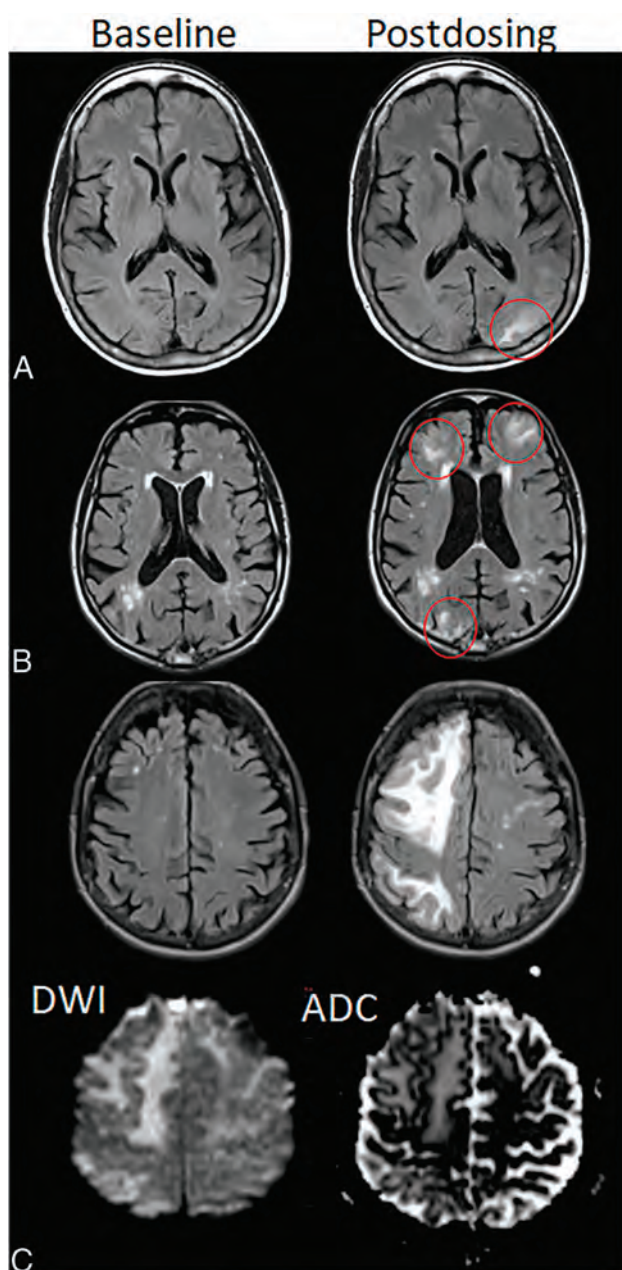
ARIA-E, parenchymal edema. Axial T2-FLAIR images from 3 separate patients at the time of the pretreatment baseline (*left*) and on a monitoring examination following initiation of anti-amyloid monoclonal antibody therapy (postdosing, *right*). *A*, On the postdosing examination, new T2-FLAIR hyperintense signal in the left parieto-occipital subcortical white matter with mild local mass effect and sulcal effacement measuring <5 cm the transverse dimension (mild ARIA-E, *red circle*). *B*, New multifocal, patchy T2-FLAIR hyperintense signal in the bifrontal and right occipital subcortical white matter on the postdosing examination, each region measuring <5 cm (*red circles*). A single region measuring <5 cm would be classified as mild, but >1 yields a classification of moderate ARIA-E. Multiplicity of ARIA-E involvement yields a classification of moderate, as long as each region is <10 cm in diameter. In some regions, there is involvement of the cortex, mild local mass effect, and gyral swelling. *C*, On the postdosing examination, development of extensive T2-FLAIR hyperintense signal throughout the right frontal and parietal lobes measuring >10 cm (severe ARIA-E). Associated mass effect and sulcal effacement throughout much of the right cerebral hemisphere.
